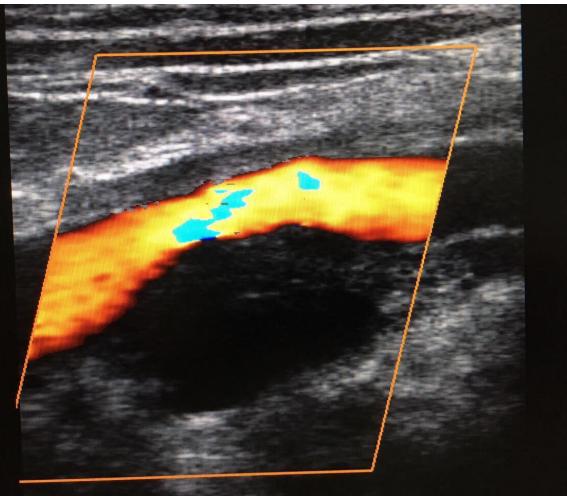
Preoperative Doppler of popliteal region evidencing probable cystic mass without flow in its interior.
